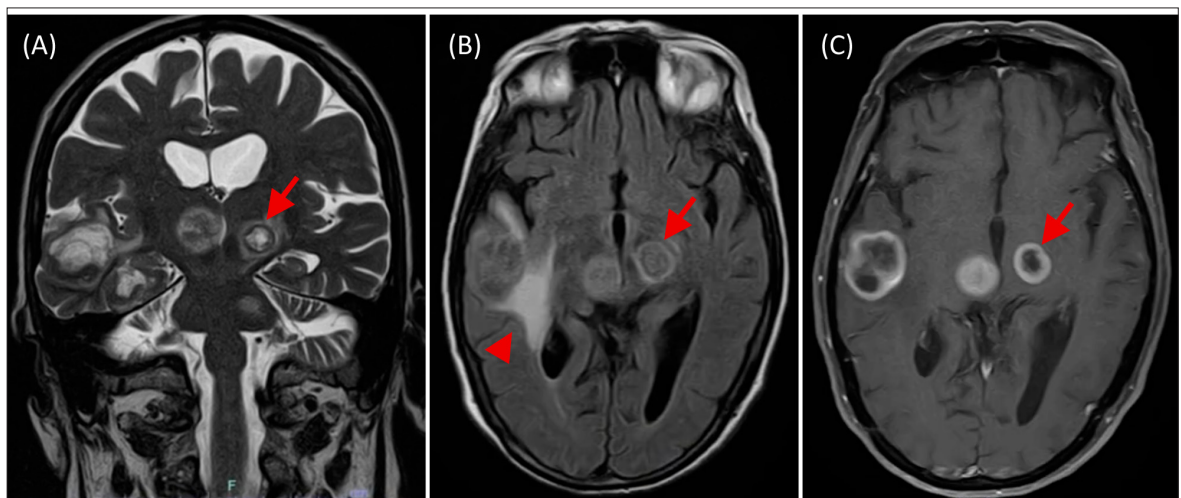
Brain MRI. (A) Coronal T2-weighted image, (B) axial FLAIR image, (C) Axial post-contrast T1-weighted image, showing multiple supra- and infratentorial secondary lesions, including the left subthalamic nucleus (arrows). This lesion caused right-sided hemichorea-hemiathetosis, which led the patient to the emergency department. Additional lesions can be seen in the right subthalamic nucleus, right thalamus, right lateral and medial temporal lobe and left lateral pons. The right temporal lesion is surrounded by significant vasogenic edema (arrowhead).
